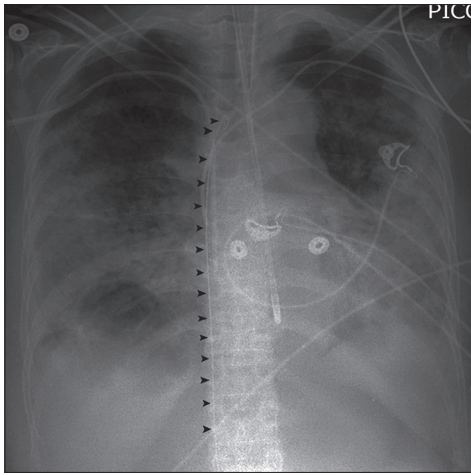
Chest X-ray showing misplaced guide wire
